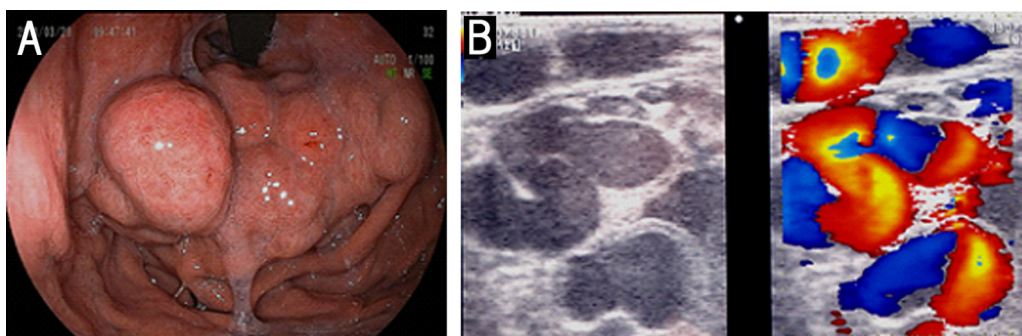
(A) Endoscopic imaging of a patient who underwent intraoperative conversion to open surgery showed large gastric varices at the fornix. (B) Intraoperative color Doppler laparoscopic ultrasonography imaging outside the gastric wall. It showed high blood flow in the variceal vessels before devascularization.
